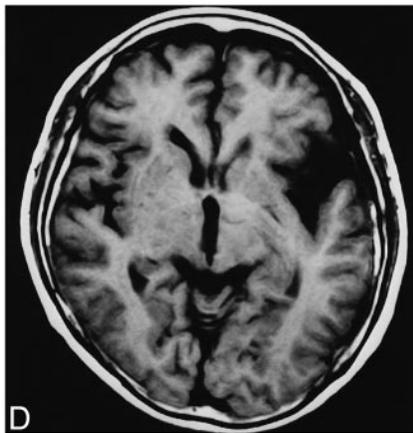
MR imaging after CT study.
